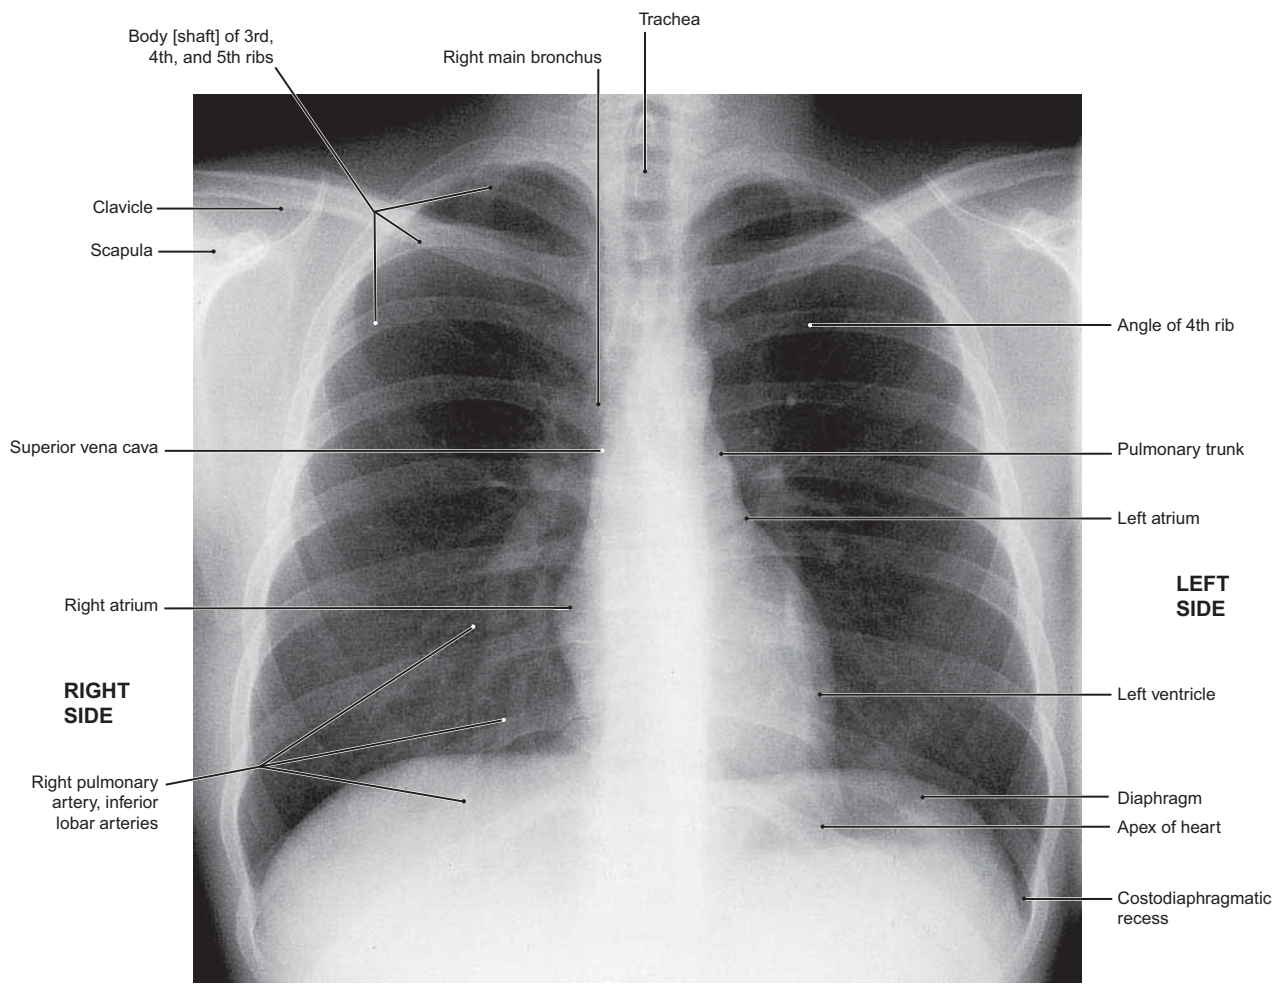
Posteroanterior Radiograph of the Thorax in a 27-Year-Old Male
